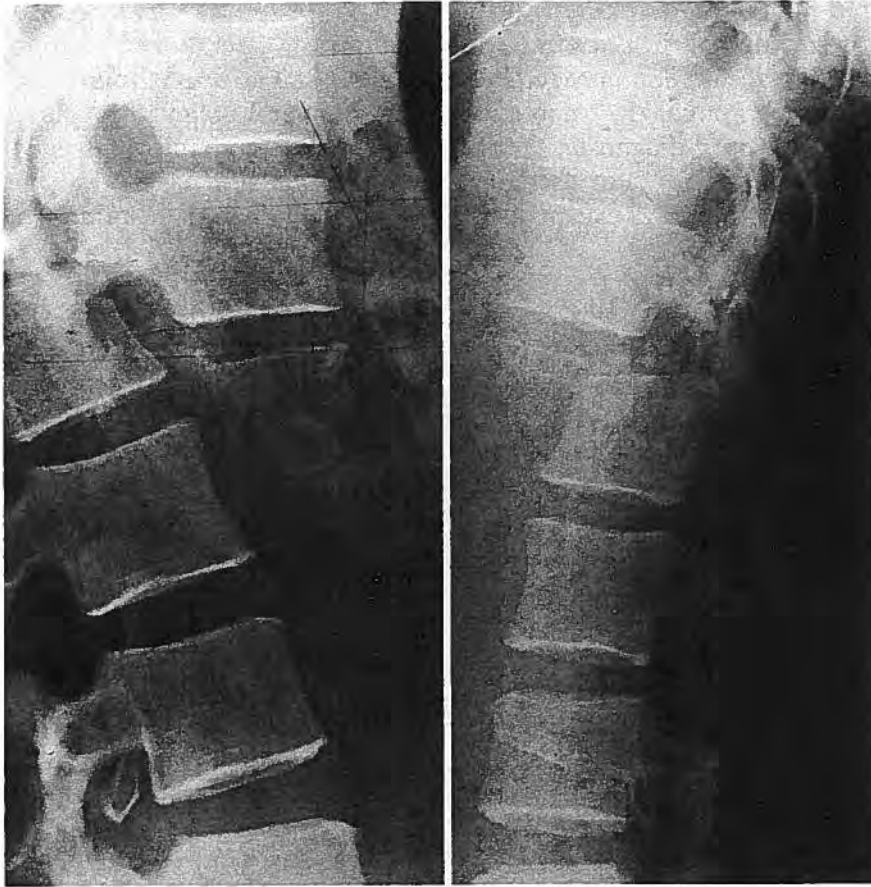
Fracture-dislocation of T12/L1. Posturing has assisted in obtaining better radiographs
